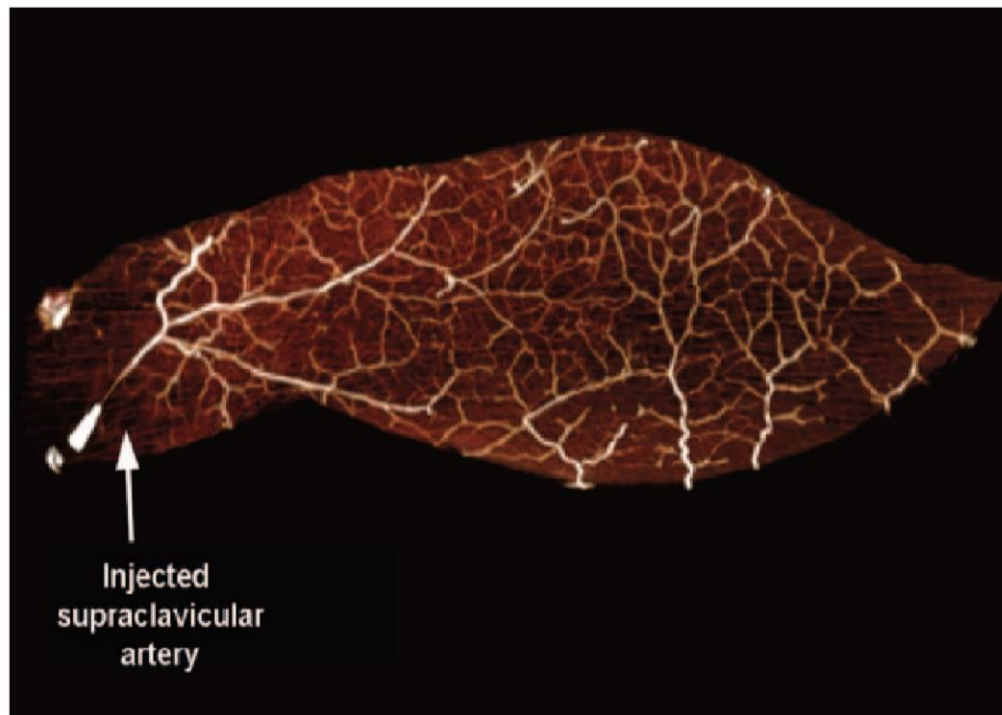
Three-dimensional computed tomographic angiogram of a supraclavicular flap (anteroposterior view). The flap was infused almost 100 percent (25).
